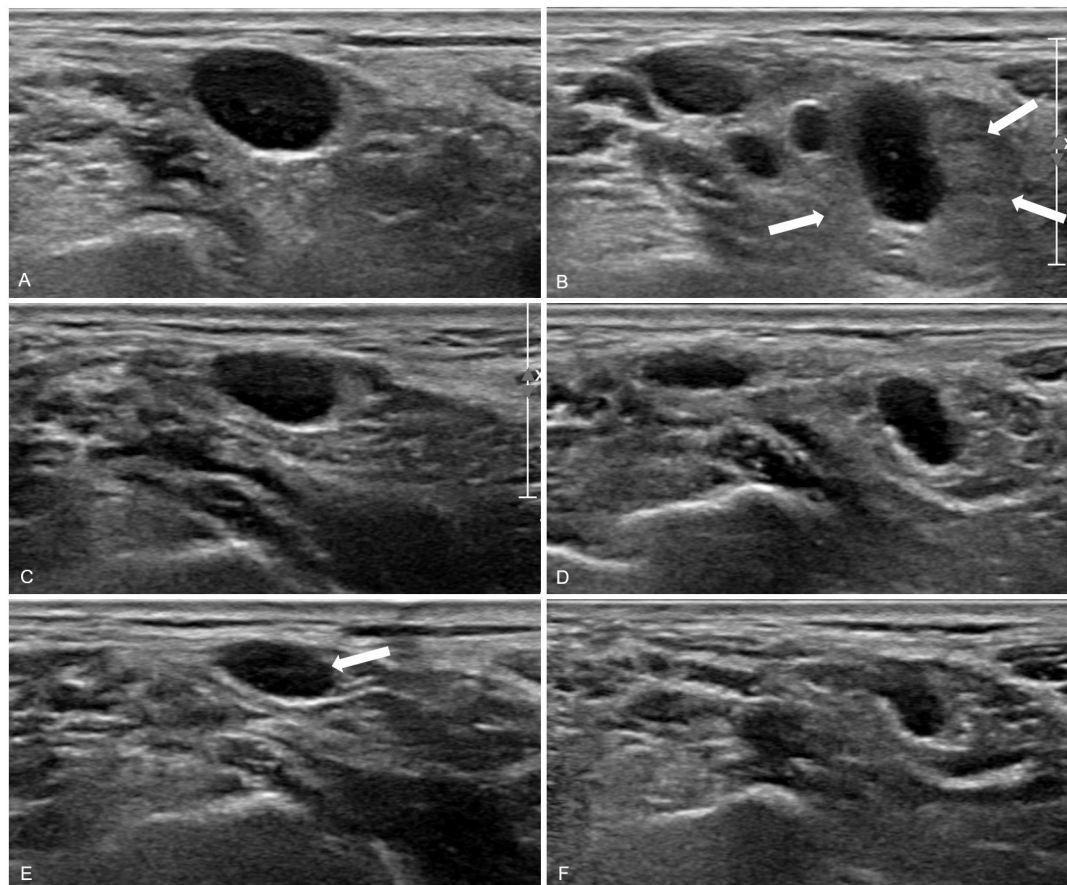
Left supraclavicular lymphadenopathy that developed 10 days after the first dose of Pfizer–BioNTech COVID-19 vaccine in the left arm. (A and B) Ultrasonography performed on the left supraclavicular region 18 days after the first dose of vaccination demonstrated multiple enlarged (measuring 1.2×0.7 cm and 0.9×0.7 cm, respectively), cortically thickened lymph nodes with loss of normal fatty hilum and an ill-defined border with perinodal fat hyperechogenicity (marked arrows in B). (C and D) One-week follow-up sonography showed decreased size (measuring 0.8×0.4 cm and 0.7×0.5 cm, respectively) and decreased extent of perinodal fat hyperechogenicity of the lymph nodes. (E and F) Another one-week follow-up sonography showed further decreased size (measuring 0.8×0.3 cm and 0.5×0.3 cm, respectively) of the nodes with normalization of cortical thickness and some identifiable fatty hilum (marked arrow in E).
